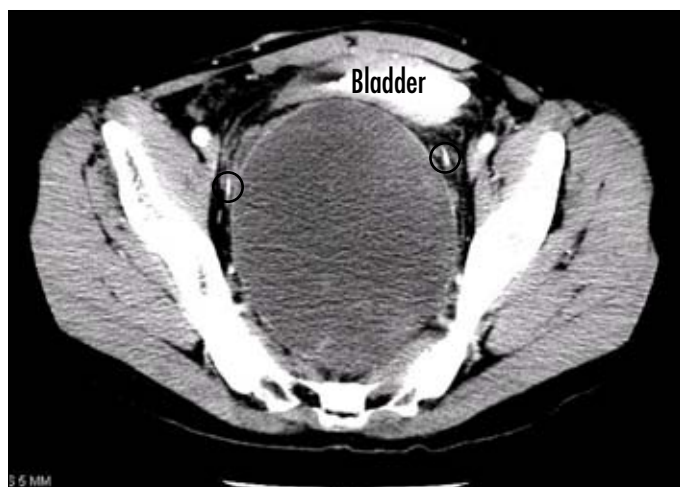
A computed tomography demonstrating a large cystic pelvic mass with mixed attenuation. The relationship of the mass to the ureters (circled) and bladder is shown.
